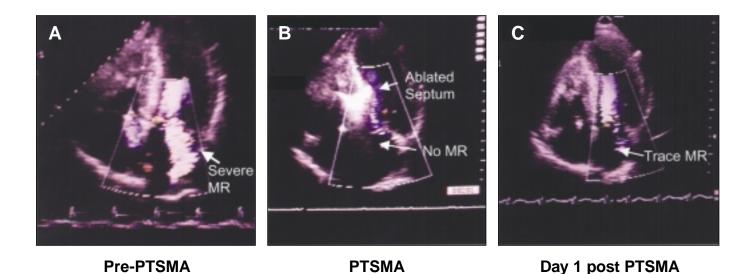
Changes of mitral regurgitation after PTSMA. A. There is severe eccentric mitral regurgitation(MR) at baseline. B. There is a bright echogenic basal septum just after PTSMA, with no MR. C. Echocardiogram done one day post procedure showing only trace MR.
